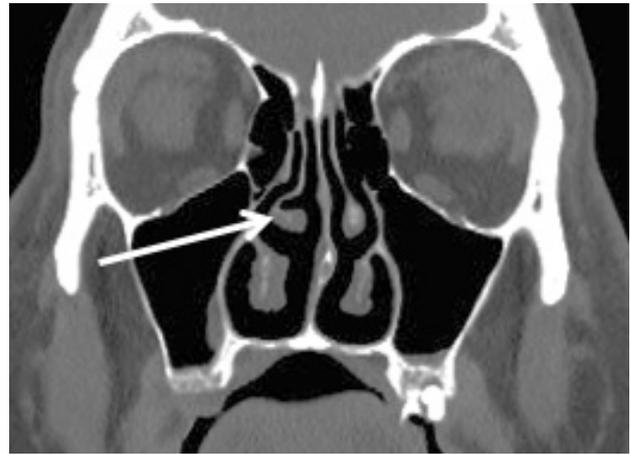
Coronal CT showing Paradoxical Middle Turbinate(PMT) on the right side (arrow)
